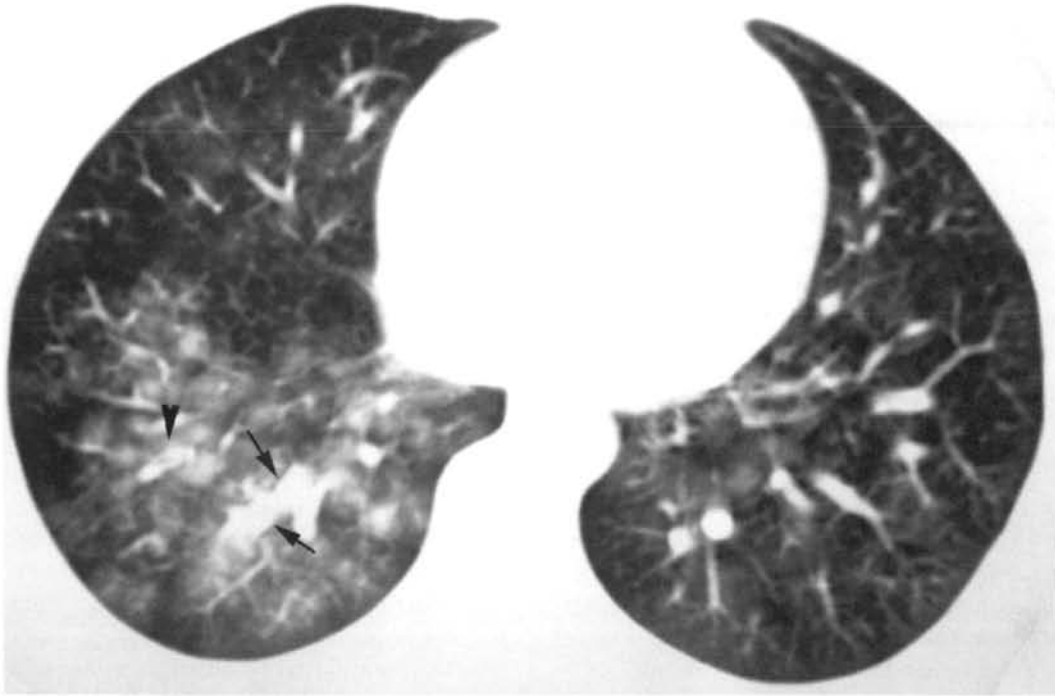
CT scan of a 38-year old woman with repeated haemoptysis showing peribronchial cuffing (arrows), thick-walled bronchus (arrowheads) and patchy ground glass opacification consistent with haemorrhage.
